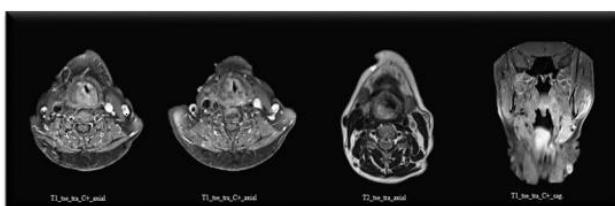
Radiological evaluation, pre-operative MRI neck.
